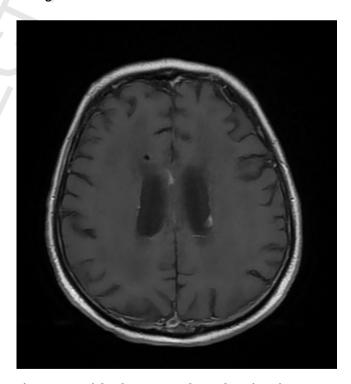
T1-weighted contrast-enhanced MR imaging presents radical regression of infiltrating changes in the right lateral ventricle wall after treatment.
